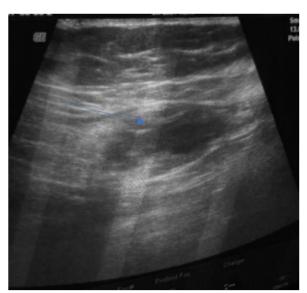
US: Intramuscular nodular formation of the rectus abdominis, oval, hypoechoic and heterogeneous, discretely vascularized on color Doppler
